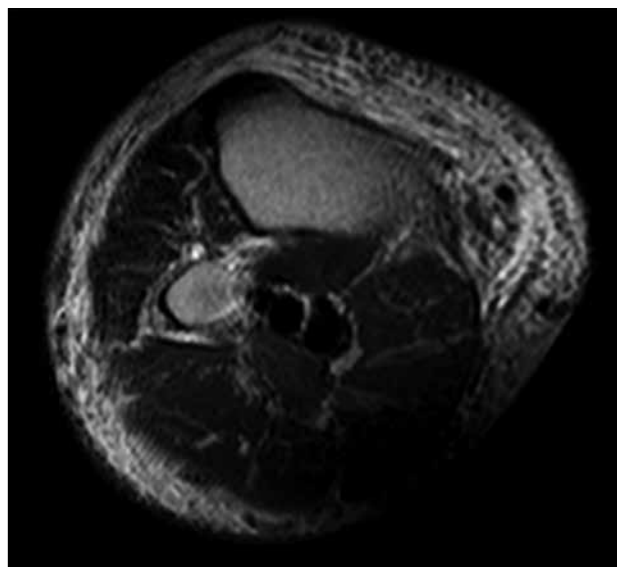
Axial T1-weighted image of the leg showing focal area of signal loss at the posterior compartment of the leg. This is due to suboptimal positioning of the coil.
